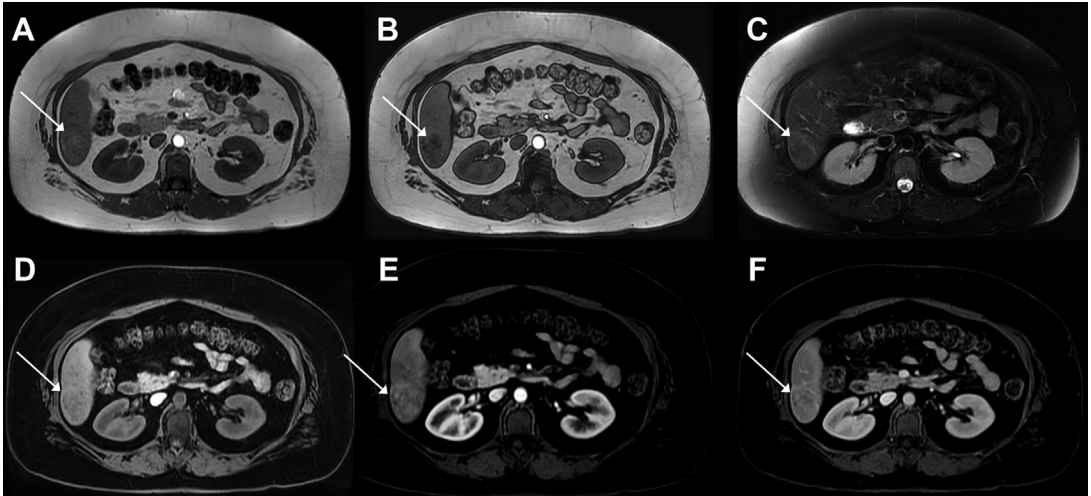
IHCA-containing fat. Fat-containing lesion, with nondiffuse dropout of signal in the opposed phase (A, B), mildly hyperintense on T2-weighted fat-saturated image (C), isointense on T1-weighted fat-saturated image (D) with arterial phase hyperenhancement (E), and persistent enhancement in the delayed phase (F) consistent with the diagnosis of inflammatory adenoma.
